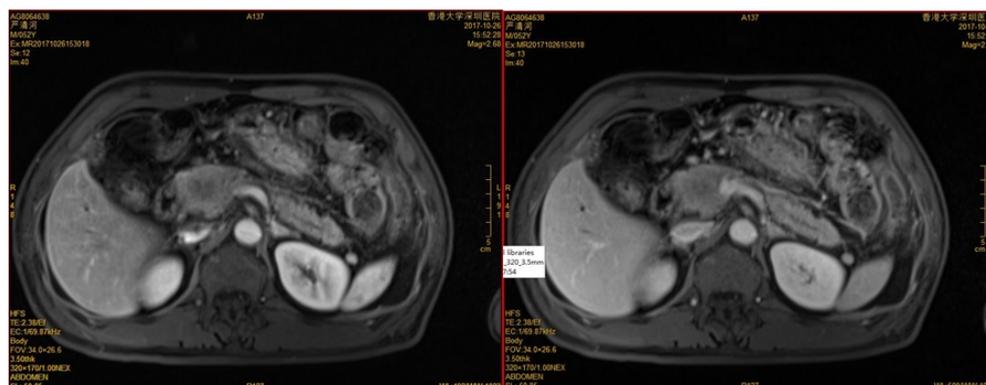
Radiographic findings: axial MR. Pancreatic head mass close to IVC
